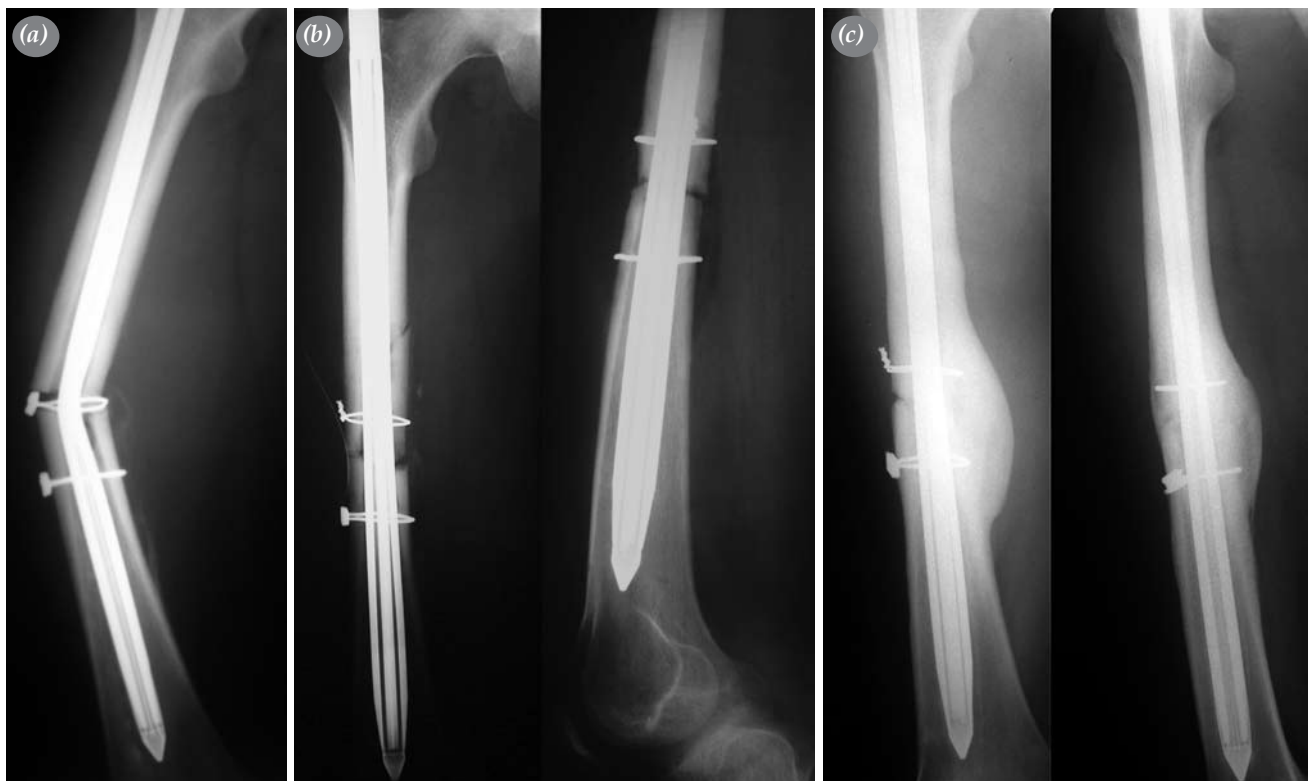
(a) 32 degrees of bending can be seen preoperatively. (b) X-rays of early postoperative period and (c) 2-years-follow-up
